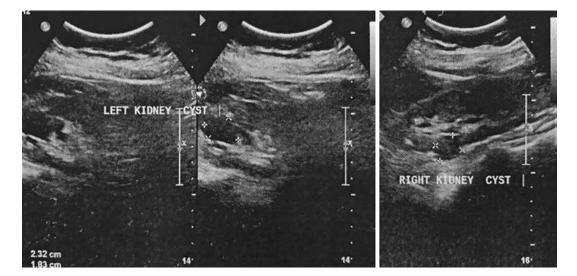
Abdominal ultrasound image of a patient with VHL showing bilateral renal cysts
